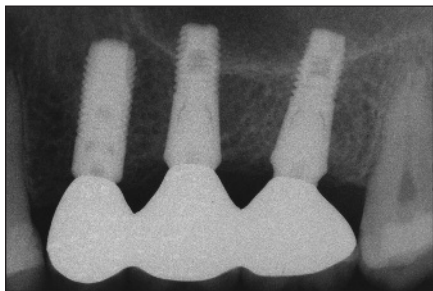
Radiograph showing excellent fit of the final prosthesis on 3 Astra implants. (Implants placed by Dr. Jeffrey Bressman.)
